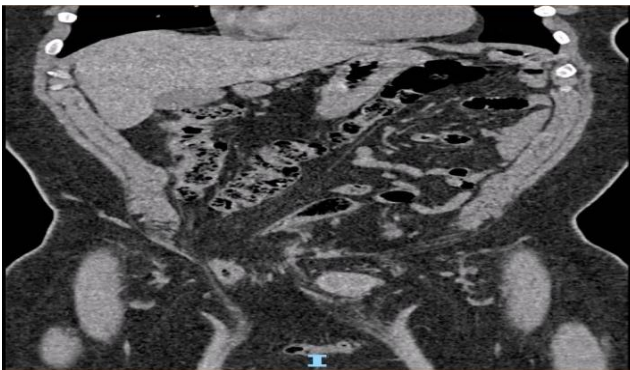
Coronal CT, right inguinoscrotal hernia containing intestinal loops.
